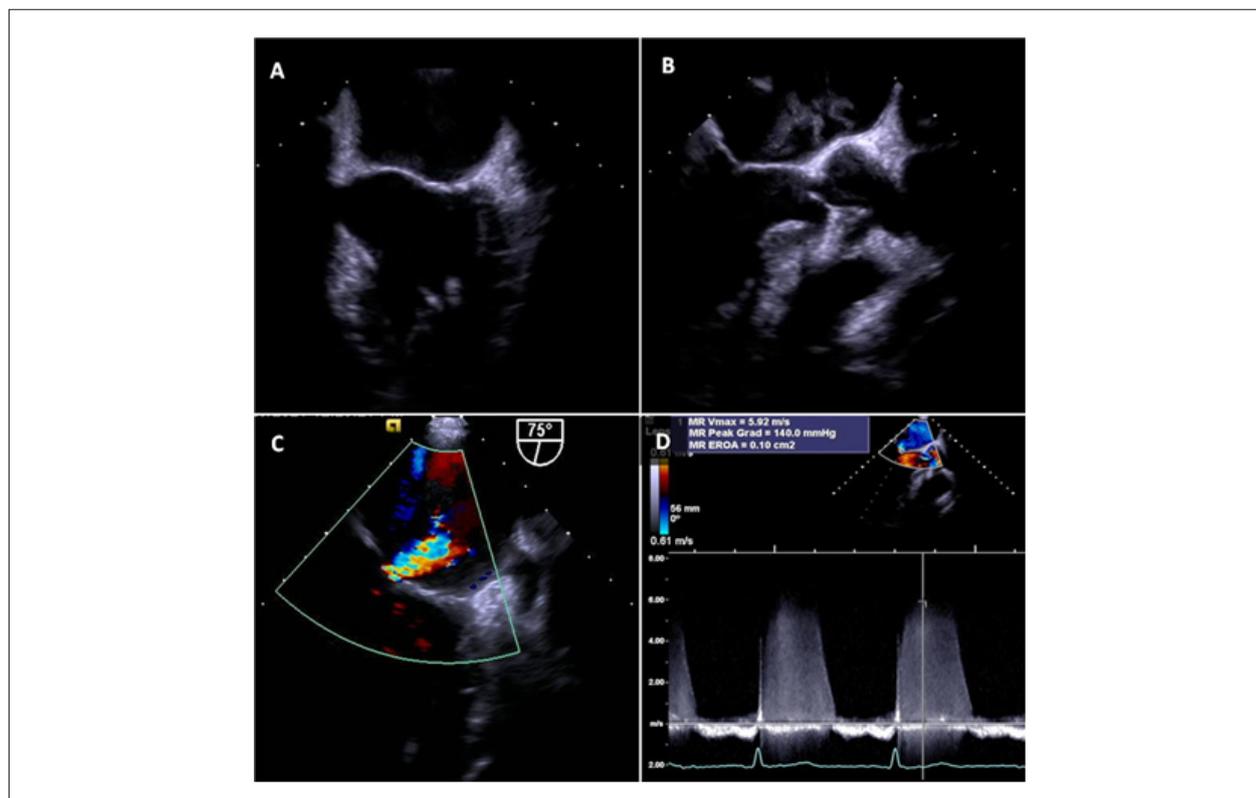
Transesophageal echocardiography performed at the 51st day of hospital stay after antibiotic therapy. It reveals complete elimination of the mitral valve vegetation (zoom view of mitral valve at 60° (A) and 120° (B)). Color (C) and continuous (D) wave Doppler revealing a mild mitral valve regurgitation (effective regurgitant orifice area of 0.10 cm² by PISA method).
